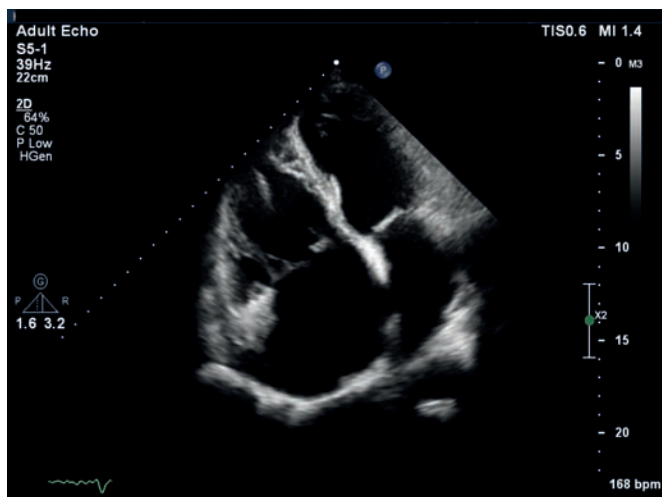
Preoperative apical 4-chamber view showing no visible right atrial mass.
